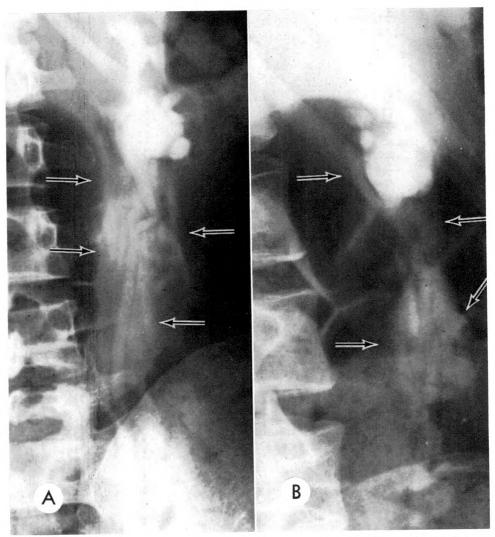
(A) A delayed 2 hour roentgenogram during excretory urography shows planes of extravasated, contrast-laden urine surrounding the renal pelvis and upper ureter (arrows). The dilated ureter, due to obstructing stones at the ureterovesical junction, is clearly seen and outlined by radiolucent periureteral fat. (B) A left oblique view at the 2 hour period shows the complete encompassing of the pelvis and upper ureter (arrows).
